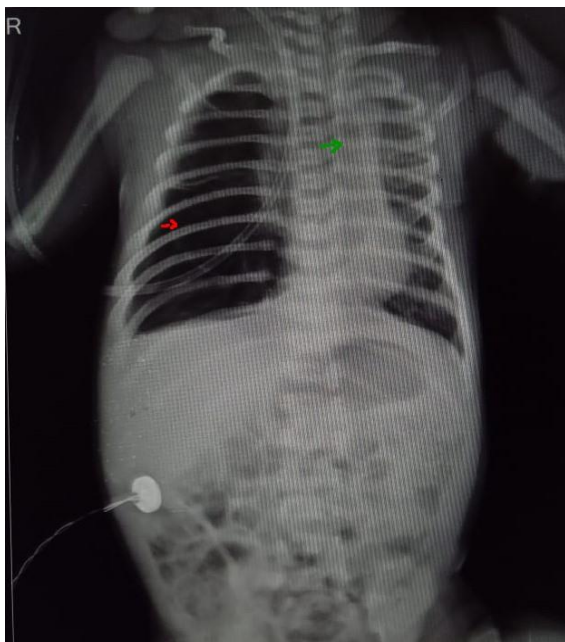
X-ray chest showing hyperlucent right lung (red arrow) with significant mediastinal shift towards left (green arrow) and compression of left lung
